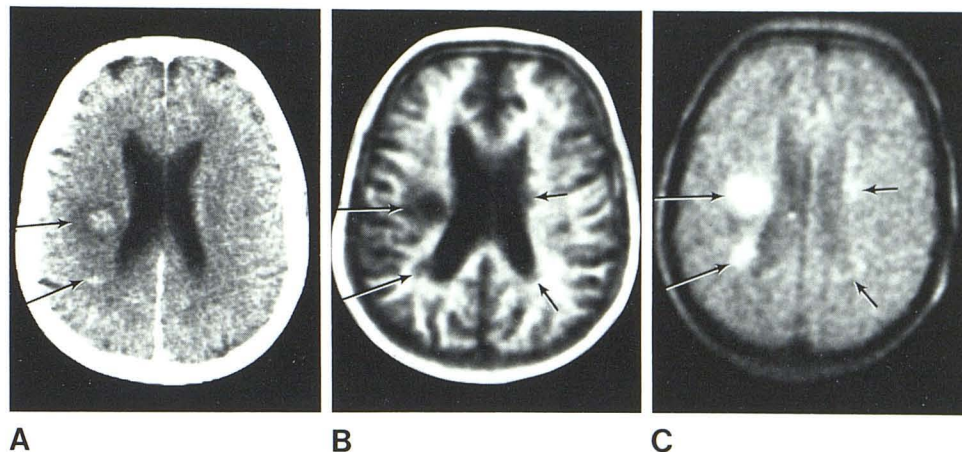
Multiple sclerosis. A, Contrast-enhanced CT. B, IR_{1400/400}. C, SE_{1080/40}. Contrast-enhancing lesions on CT scan (A) are seen with both NMR scans (long arrows). Two other lesions only demonstrated with NMR (short arrows).
